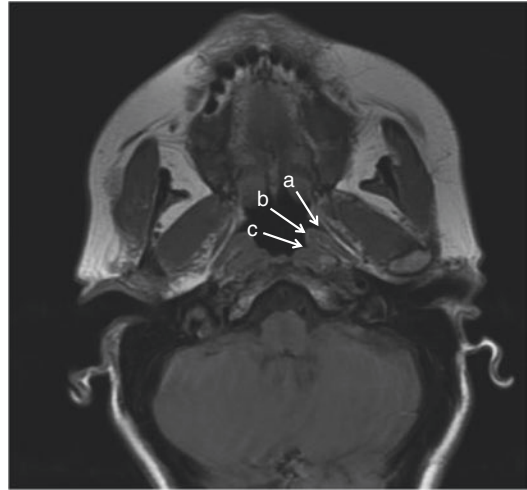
Axial T1W MRI at the level of the nasopharynx: (a) Eustachian tube orifice. (b) Torus tubarius. (c) Fossa of Rosenmuller
